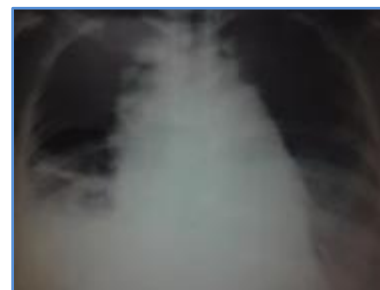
X-ray of the patient showing Rt. Pleural effusion with enlarged mediastinal shadow
